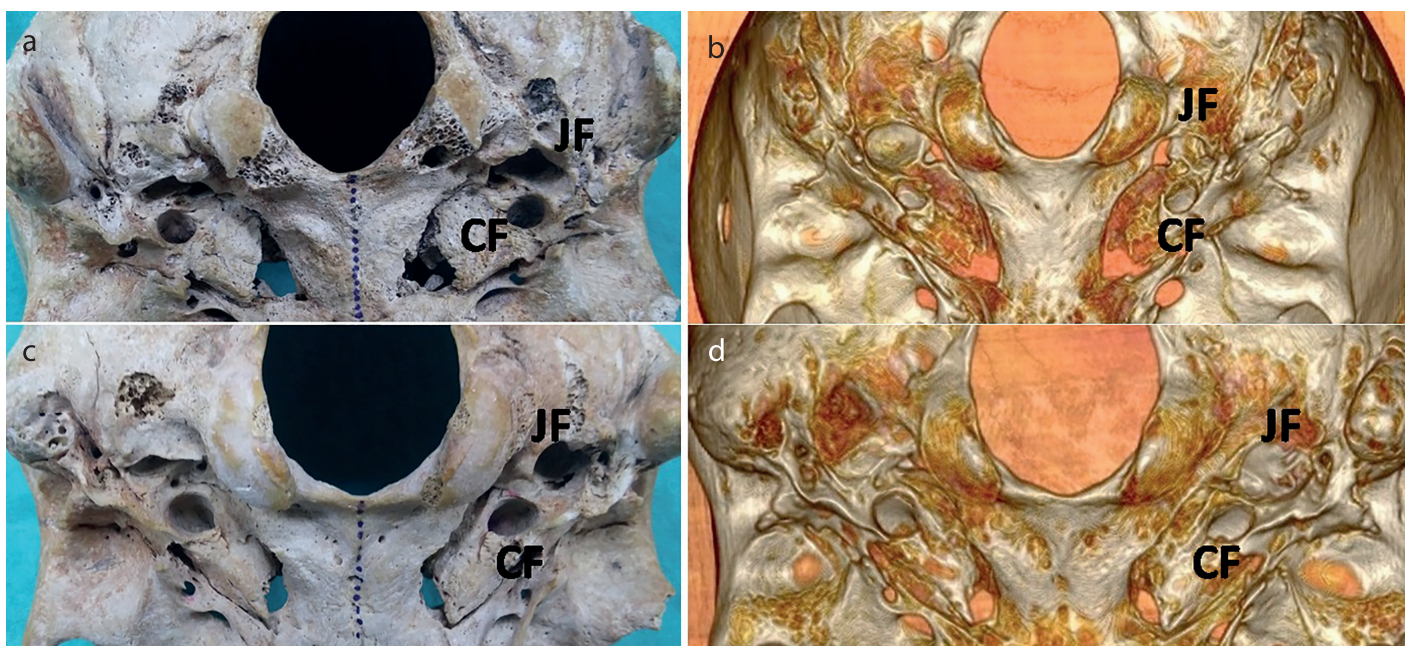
a-d. The photographs show the position of CF according to the jugular foramen in dry skulls and CT. a, b) anterior and c, d) antero-medial.
